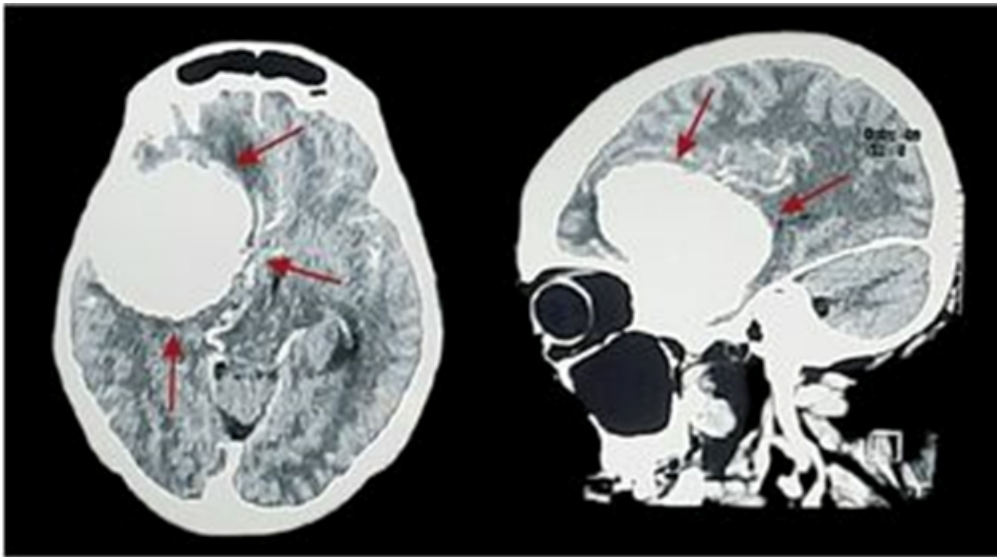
Head CT Scan Images in Axial and Sagittal View.
